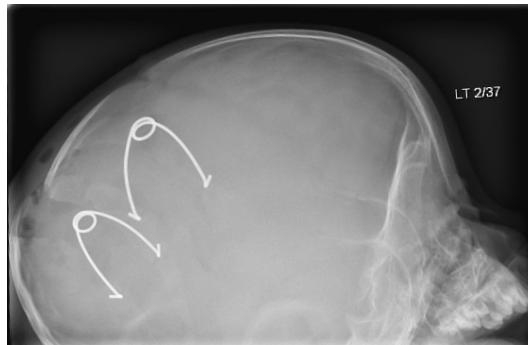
X-ray image of Patient 4 implanted with 2 lateral springs.
